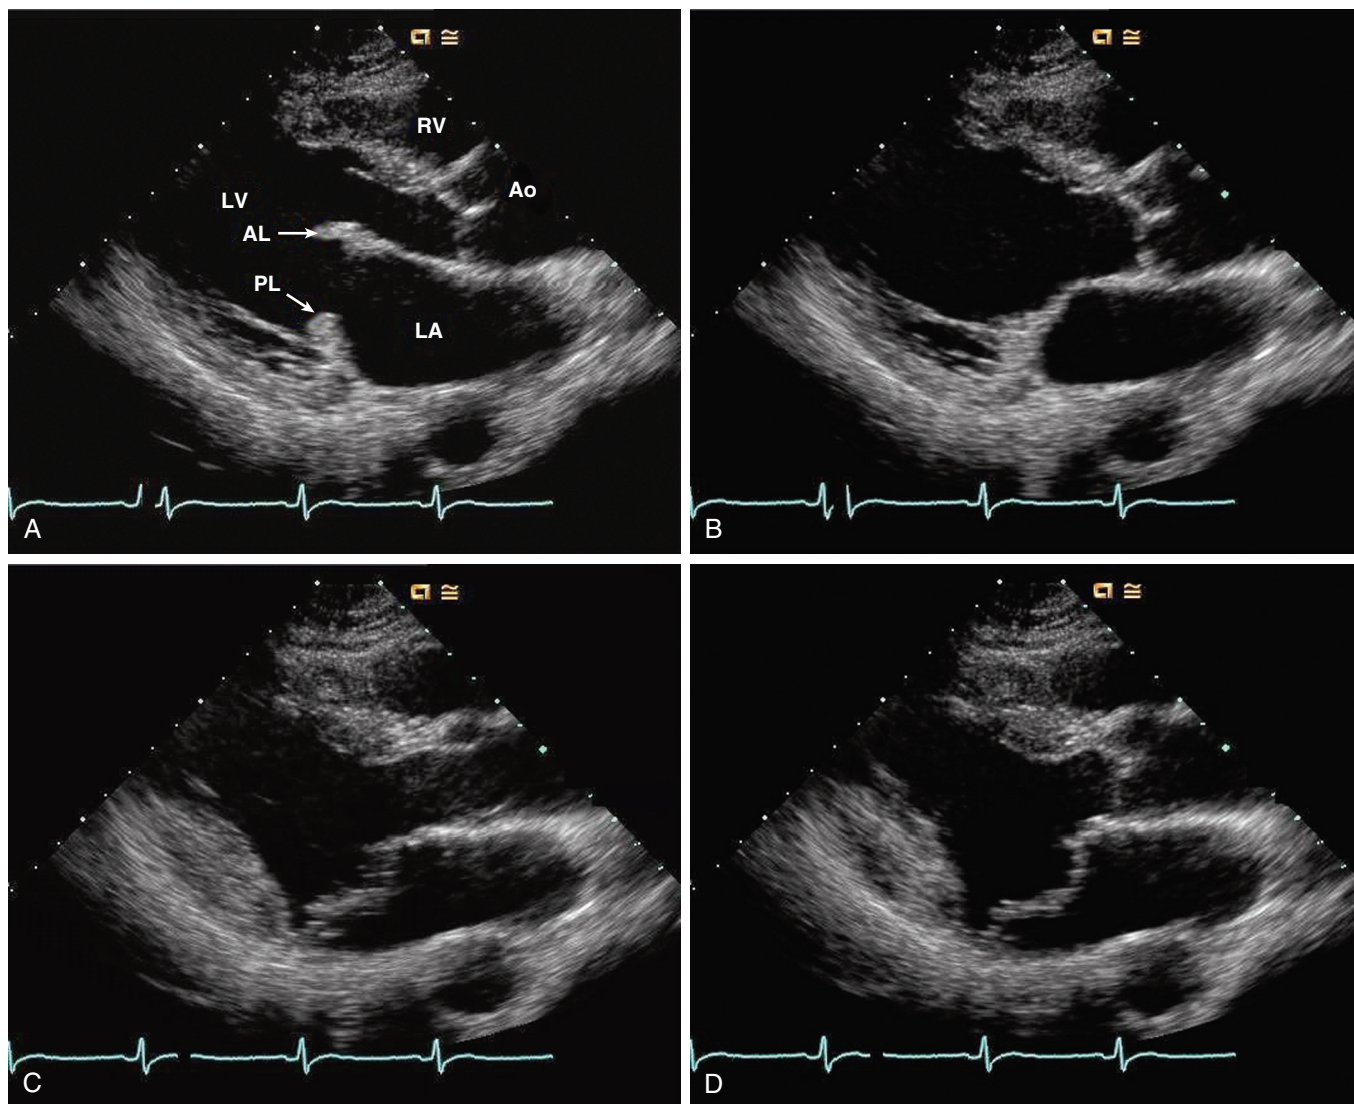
FIGURE e63-6 Parasternal long-axis two-dimensional echocardiographic images obtained in a 41-year-old man with MVP and auscultatory findings of a midsystolic click and MR. A, End-diastolic image. The mitral valve leaflets are severely thickened, and the anterior leaflet (AL) is elongated. B-D, Serial images from early systole to midsystole demonstrating bileaflet prolapse. Color flow imaging in this patient demonstrated severe MR. Patients with these findings are at increased risk of complications, such as infective endocarditis, systemic emboli, and heart failure. Ao = aorta; LA = left atrium; LV = left ventricle; PL = posterior leaflet; RV = right ventricle.
